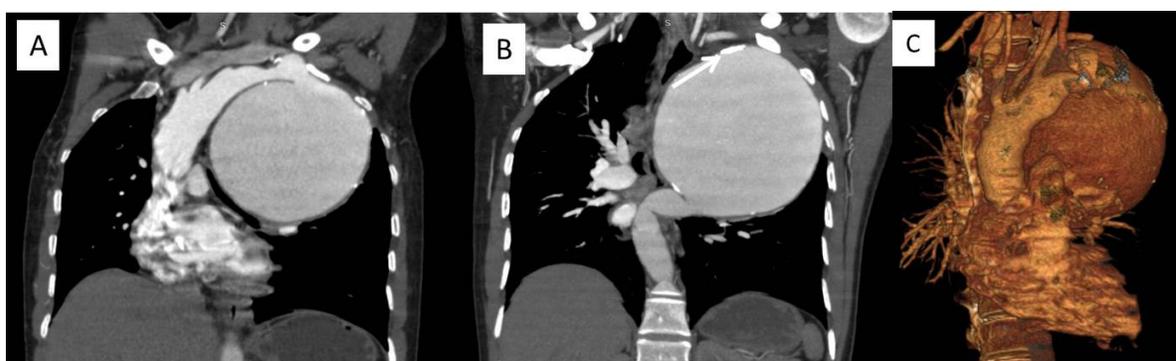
CT angiography coronal multiplanar reformatted (MPR) (A,B) and volume rendered (VR) images (C) showing a large fusiform aneurysm involving proximal descending thoracic aorta with peripheral discontinuous calcification (arrow in B) in its wall.
